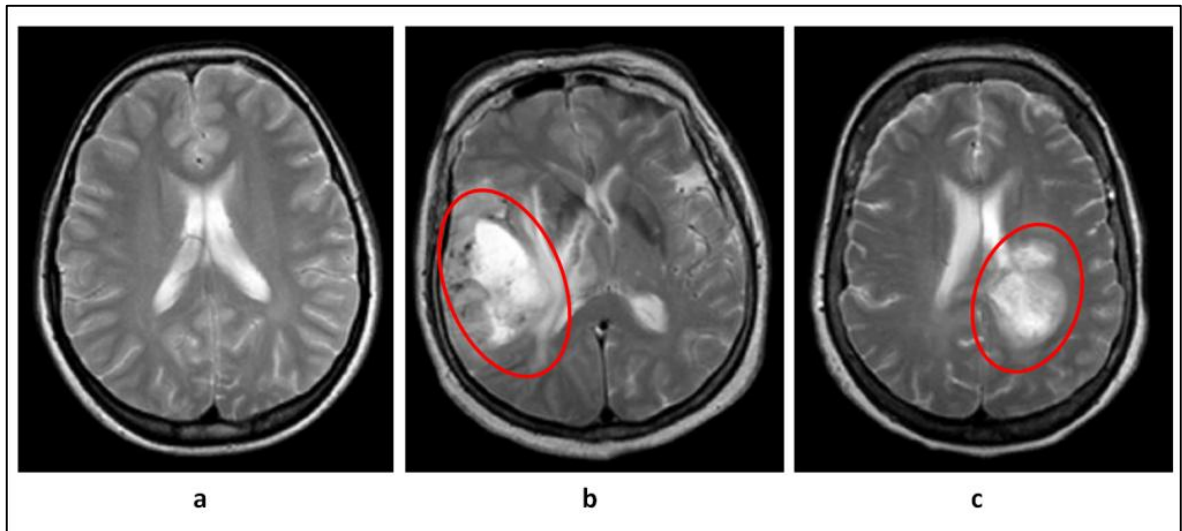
MR images of (a) a healthy brain, and (b) Grade II, (c) Grade IV brain tumors.
